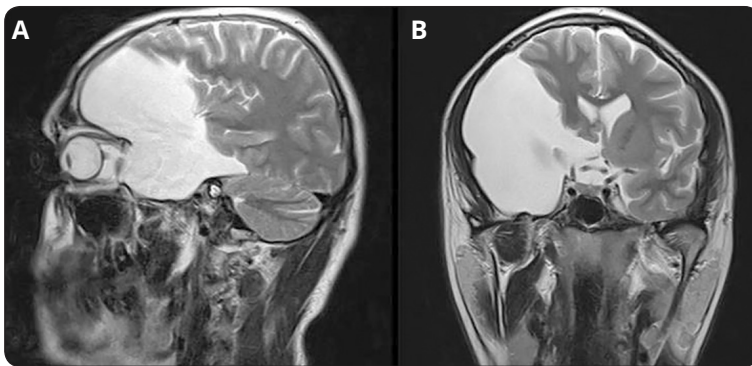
Preoperative coronal and sagittal MRI of a Type III Sylvian arachnoid cyst treated by microsurgery
